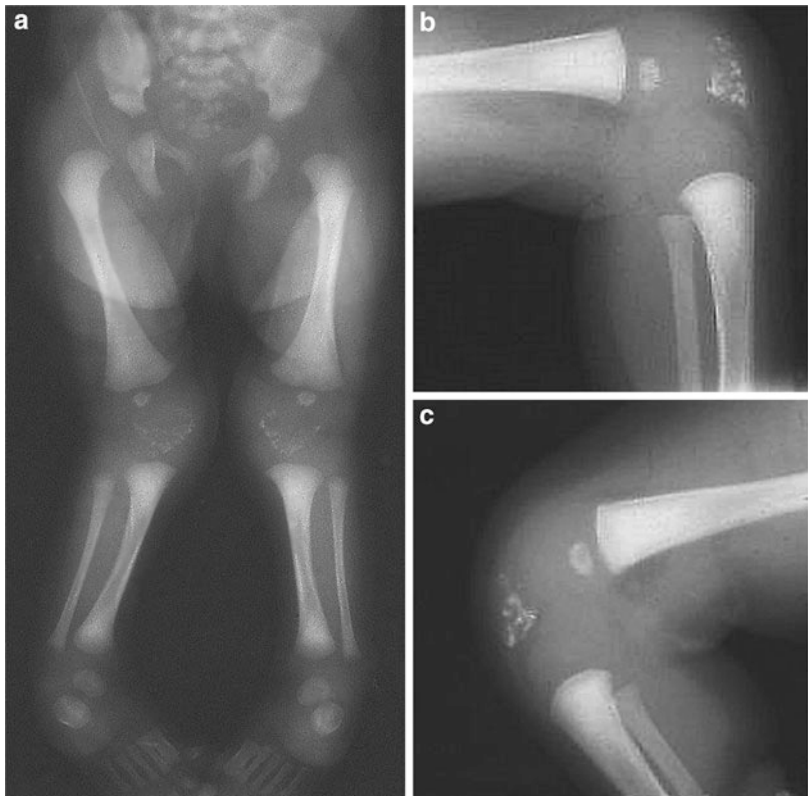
(a–e) This Caucasian newborn baby girl (a) was born at 36 weeks' gestation secondary to polyhydramnios. The baby was noted to have rhizomelic shortening of the extremities. The radiographs (b–e) showed multiple punctate calcifications (stipplings) throughout spinal column and in the epiphyses of the long bones such as proximal humerus and proximal and distal femurs and calcaneus and other tarsal bones. The skin showed congenital ichthyosiform erythroderma. EBP sequencing performed by Prevention Genetic Laboratory showed that the patient is heterozygous in the *EBP* gene for a sequence variant defined as c.328 C > T that is predicted to result in the premature protein termination (p.R110X). This variant was previously reported to be pathogenic for chondrodysplasia punctata (Grange et al. 2000; Hellenbroich et al. 2007). EBP is the only gene currently known to be associated with Conradi-Hunermann syndrome (CDPX2) (chondrodysplasia punctata X-linked dominant form) (Courtesy of Dr. Gerald Whitton)
